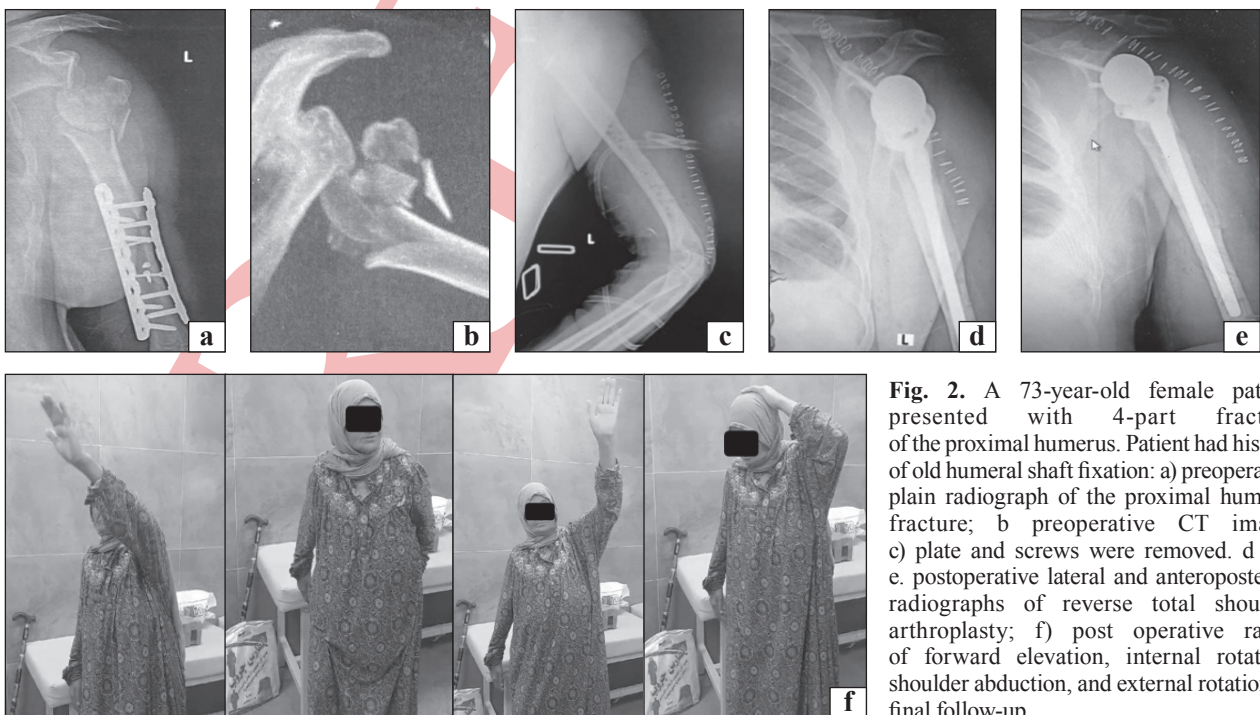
A 73-year-old female patient presented with 4-part fracture of the proximal humerus. Patient had history of old humeral shaft fixation: a) preoperative plain radiograph of the proximal humerus fracture; b) preoperative CT image; c) plate and screws were removed. d and e. postoperative lateral and anteroposterior radiographs of reverse total shoulder arthroplasty; f) post operative range of forward elevation, internal rotation, shoulder abduction, and external rotation at final follow-up
